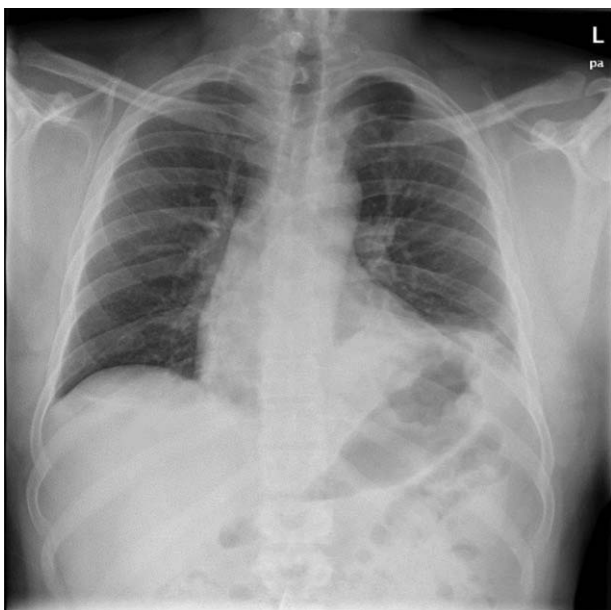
Chest X-ray showing evidence of old infection (for which patient was treated earlier) in the left lower lobe. The left hemidiaphragm is elevated.
